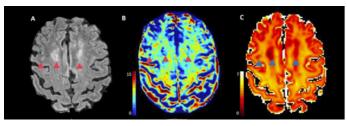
An exemplary conventional image (*D FLAIR) showing an MS lesion and of a myelin and an axon map as obtained with quantitative MRI (picture: ThINk).
